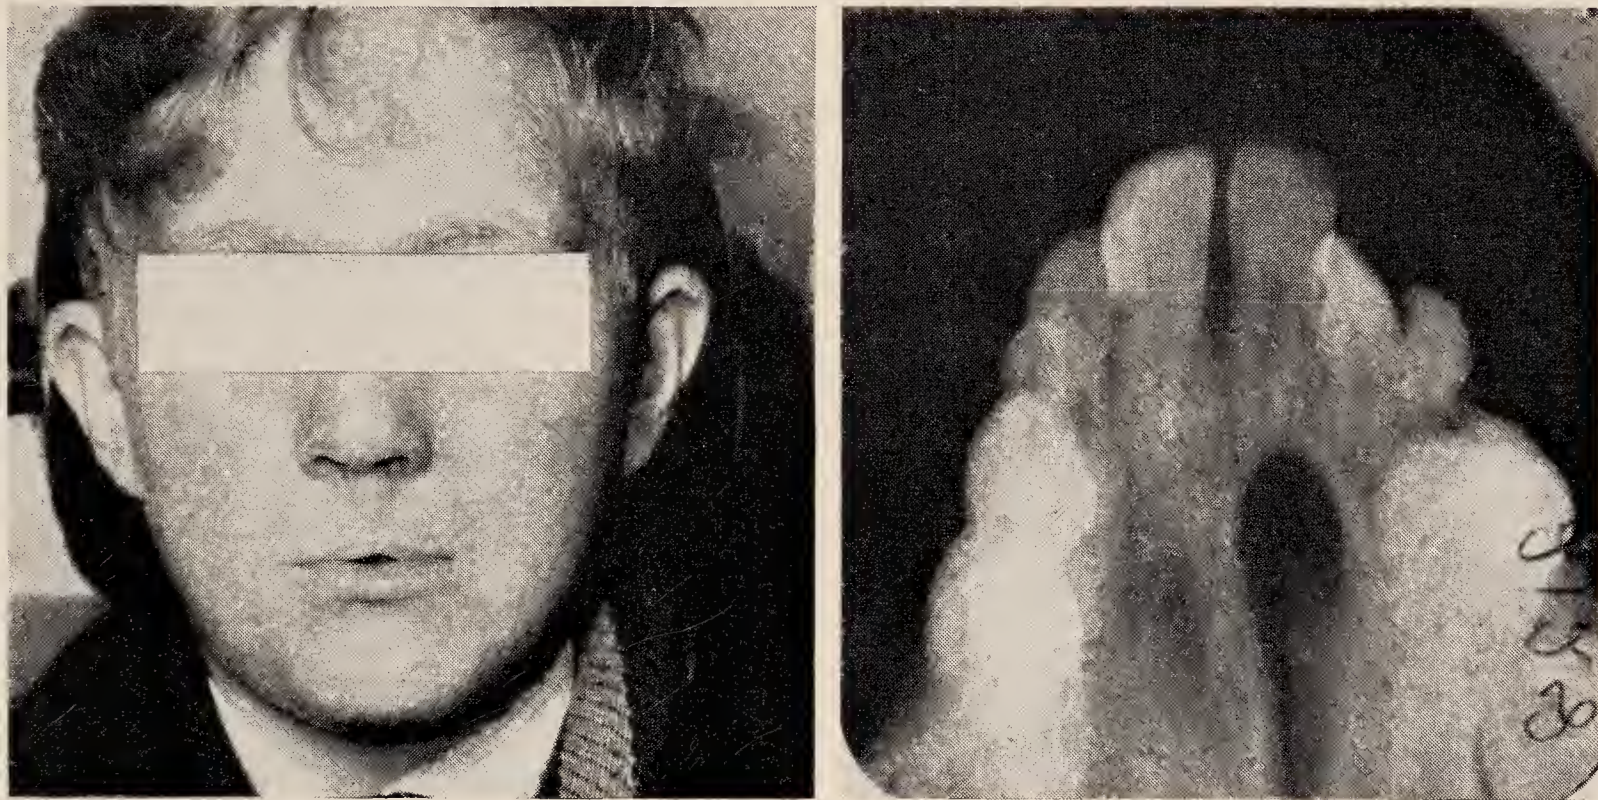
The repaired bilateral lip cleft and a radiograph showing the extent of the palate cleft in *Case 2*. It can be seen that the cleft does not extend through the alveolar process.
